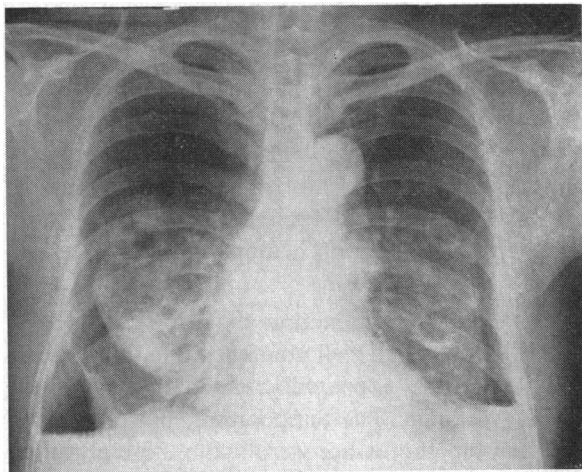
Posteroanterior roentgenogram of the chest, showing bilateral hydropneumothorax and accentuation of cystic shadows, 29 November 1960.
